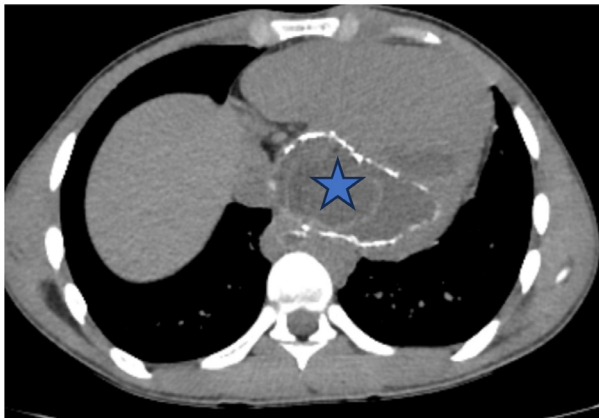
Angio-CT of the chest revealing a cystic mass with multiple septa and calcification (blue star) in the postero-inferior wall of the left ventricle, indicative of a myocardial hydatid cyst.
